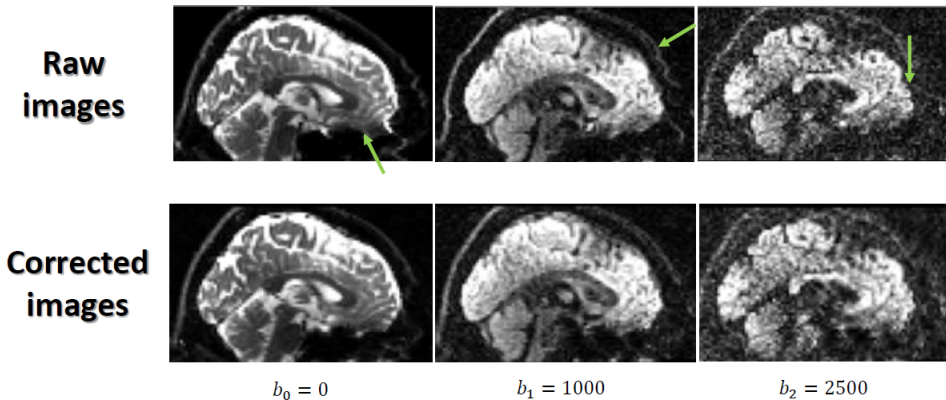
Example of raw and *Eddy* corrected DWI images, taken in the sagittal plane for the three b -values (0, 1000 and 2500 s/mm^2). Arrows point at three particularly noticeable corrected/smoothed areas.
